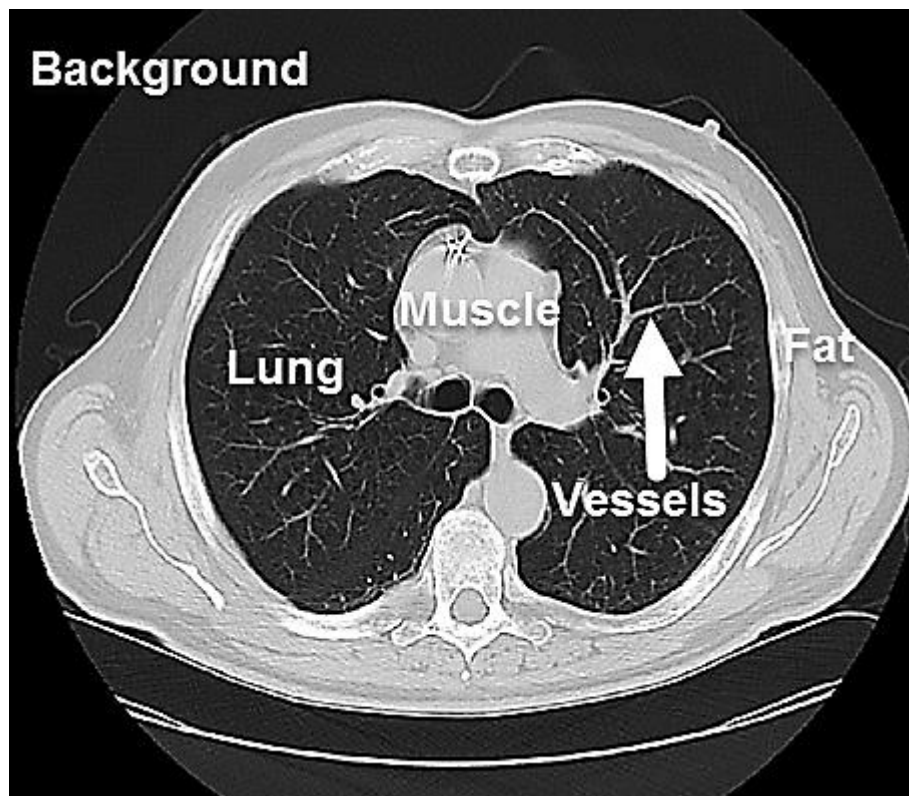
Axial lung CT image from the dataset (Lin *et al.*, 2015).
